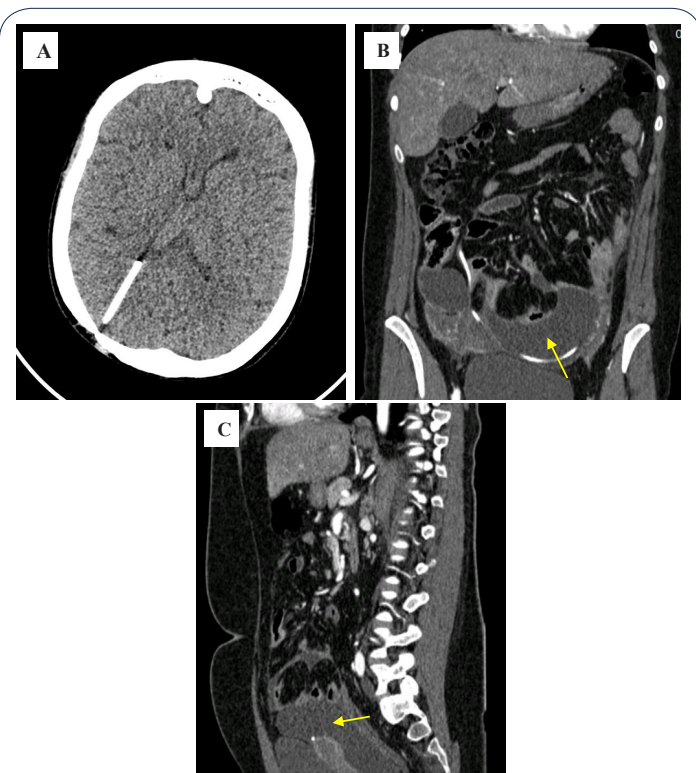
Results of Multi-Slice Spiral Computed Tomography (MSCT) performed upon admission to the hospital.
